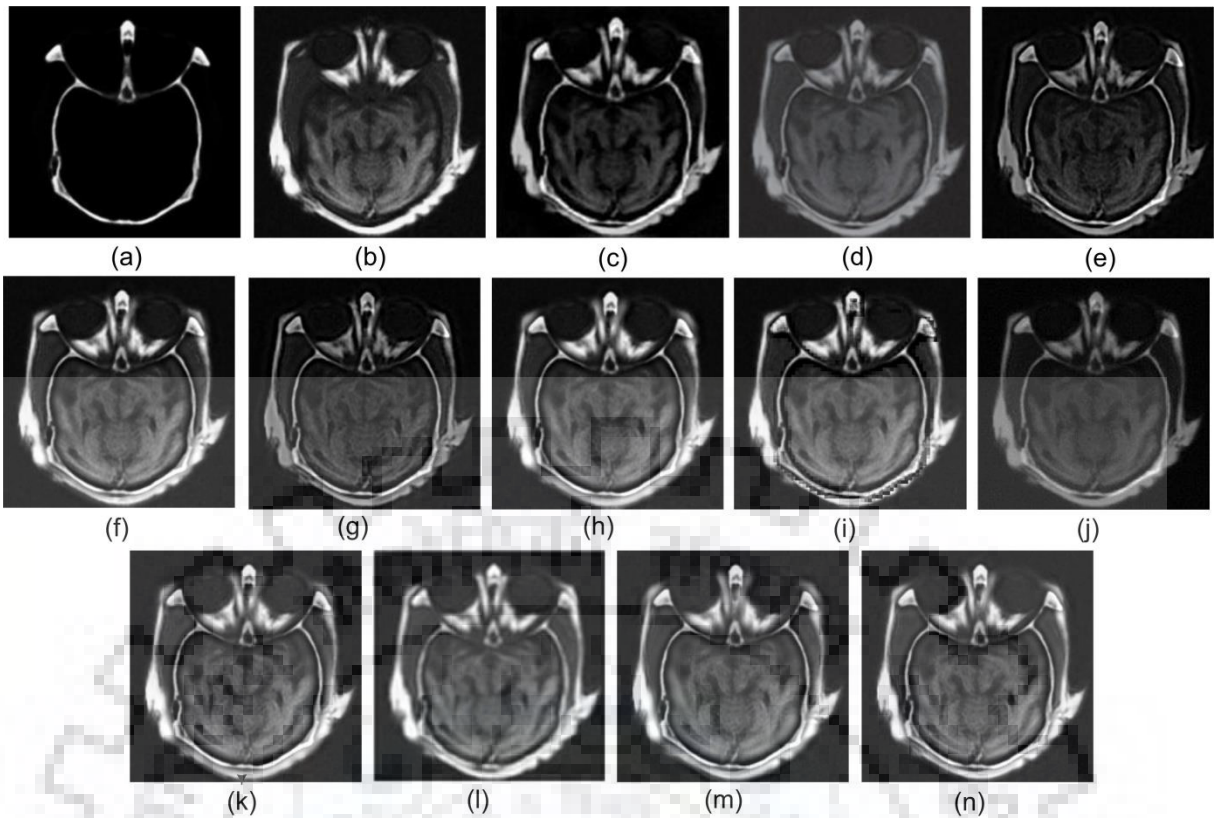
Multimodal fusion results of (a) CT image (b) MR image, and fused images obtained by the fusion (c) method [195] (d) method [154] (e) method [92] (f) method [34] (g) method [121] (h) method [55] (i) method [50] (j) method [173] (k) method [189] (l) method [23, 55] (m) NSST-MIF (n) proposed ADP-MIF approach
